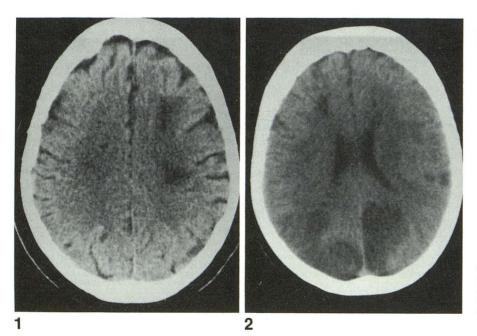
CT scan of watershed infarction at boundary of left middle cerebral artery and left anterior cerebral artery.
